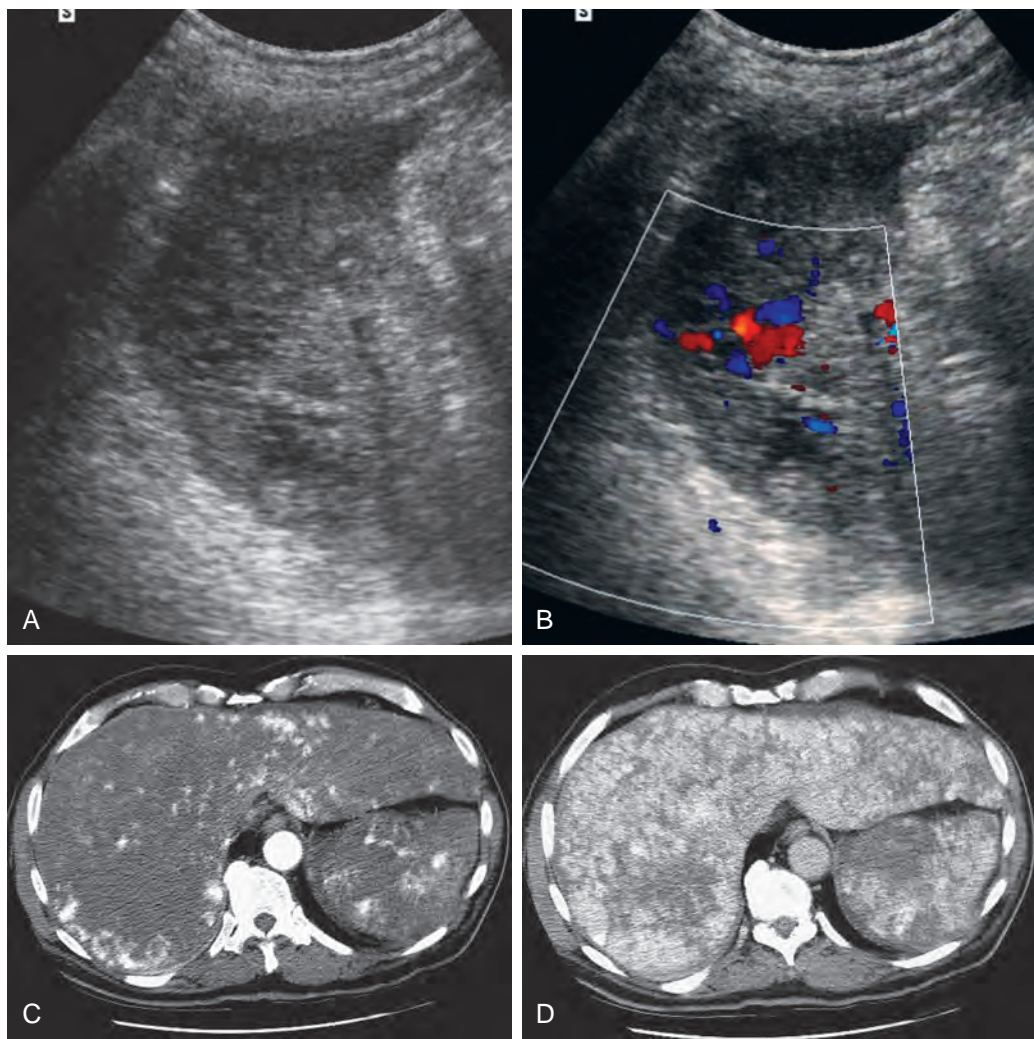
Angiosarcoma of liver and spleen. A. Ultrasound demonstrates a normal-sized, inhomogeneous spleen with a few “cystic” areas. B. Color flow is demonstrated in some of these areas, consistent with vascular lakes. C and D. CT after intravenous administration of contrast material in the arterial phase (C) and portal venous phase (D) shows many irregular areas of enhancement in the liver and spleen and areas of relatively low attenuation in the spleen. Autopsy revealed multiple angiosarcomas involving the spleen and liver. It was not possible to determine whether the spleen or the liver was the primary site.
